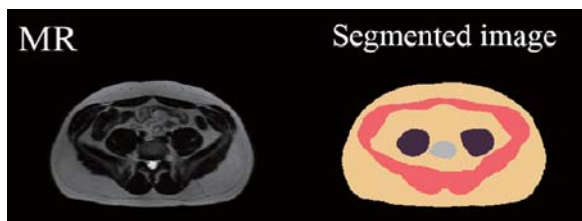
MR image (left) and segmented model (right)
